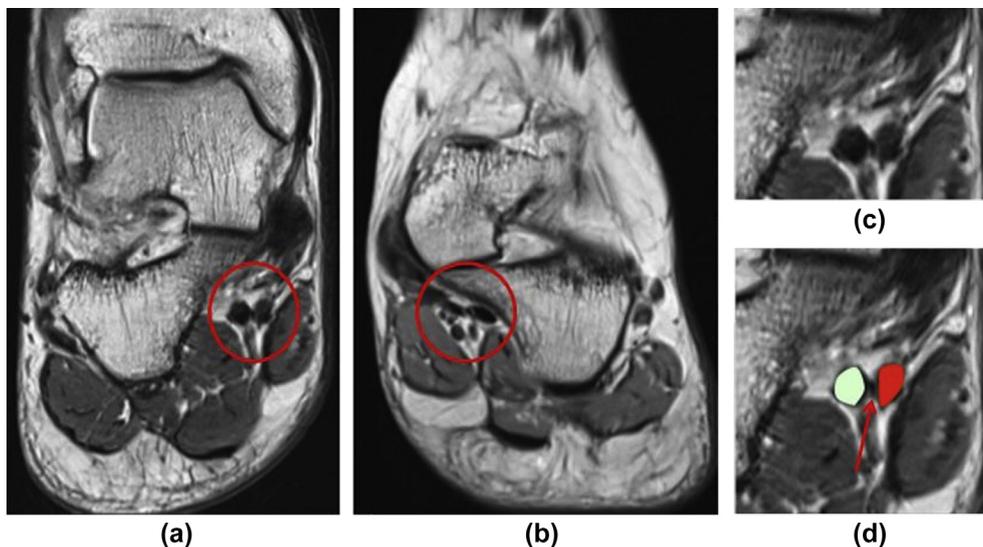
Proton-density weighted (PD) coronal MRI of two different patients (a) and (b) with a magnified view at the master knot of Henry. (c,d) A linear hypointense slip (red arrow) connecting the FHL (green) and FDL (red) tendons. The location and identification of this slip is crucial in knowing where to harvest the FHL tendon for grafting.
